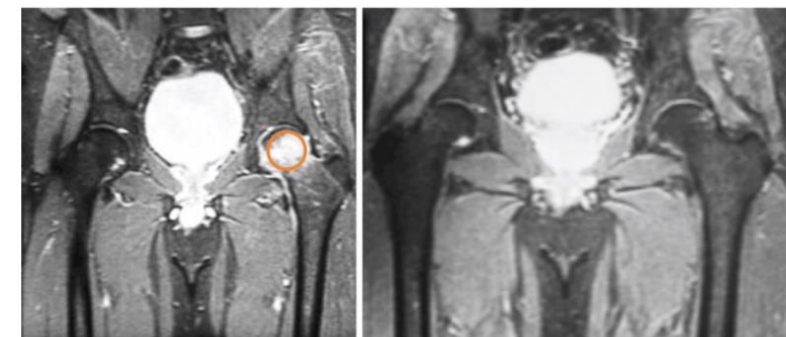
Pre- and 6 months post-treatment T2-weighted images of the same patient
